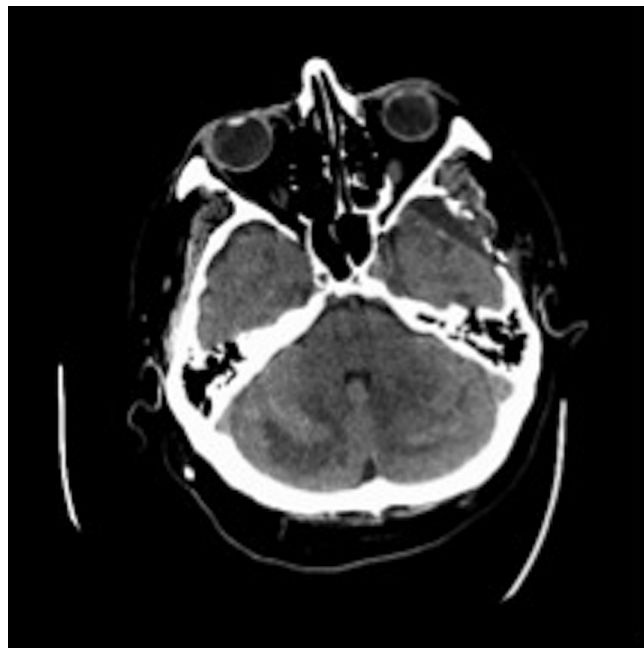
Patient 1. Axial head CT scan on the eighteenth postoperative day showing evolution of the remote cerebellar hemorrhage with effacement of the fourth ventricle and perimesencephalic cisterns.
